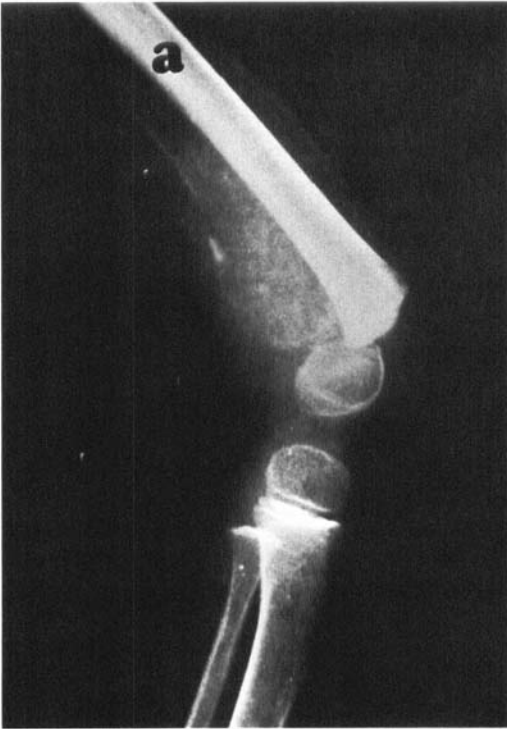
Roentgenographs showing the displaced distal femoral epiphysis with a typical ossifying subperiosteal hematoma.
